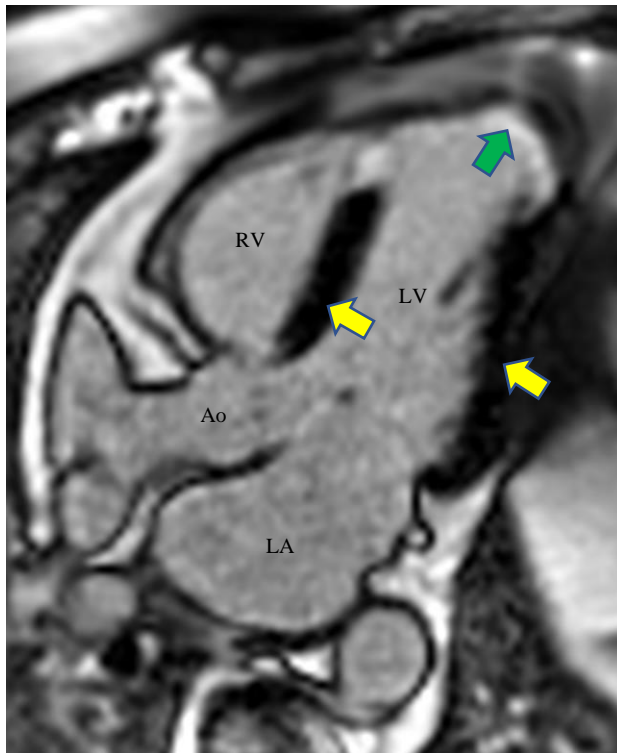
Apical three chamber view showing late gadolinium enhancement. In areas of focal extracellular space expansion, the myocardium appears white (green arrow) and in areas of healthy tissue the myocardium appears black (yellow arrows).
